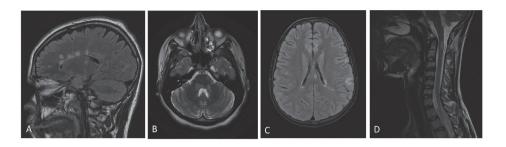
MRI predilection sites for multiple sclerosis
